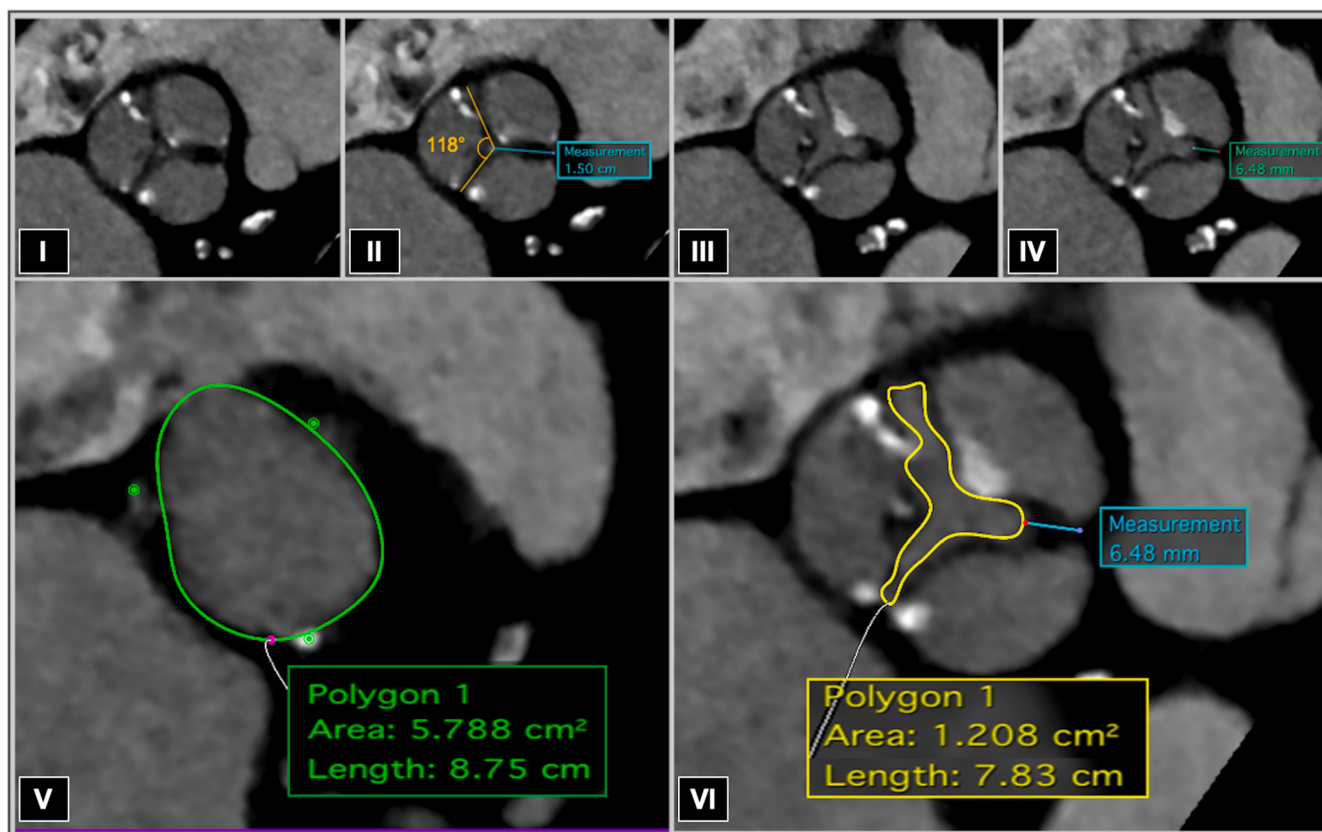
CT assessment of forme fruste BAV. In diastole, this BAV phenotype mimics a tricuspid configuration with three symmetric cusps (I–II). Full-cycle analysis reveals a mini-raphe in systole (III–IV). After confirmation of forme fruste BAV, the Level of Implantation at the Raphe (LIRA) method is applied by comparing the perimeter measured at the virtual basal ring (VBR, V) with that measured at the level of maximal raphe protrusion (LIRA plane, VI). When the LIRA perimeter is smaller than the VBR perimeter, prosthesis sizing is driven by the LIRA measurement. In this case, annular sizing based on a VBR perimeter of 87.5 mm would have suggested a 34-mm Medtronic prosthesis, whereas a LIRA perimeter of 78.3 mm led to the selection of a 29-mm Medtronic prosthesis. Abbreviations: BAV, bicuspid aortic valve; CT, computed tomography.
